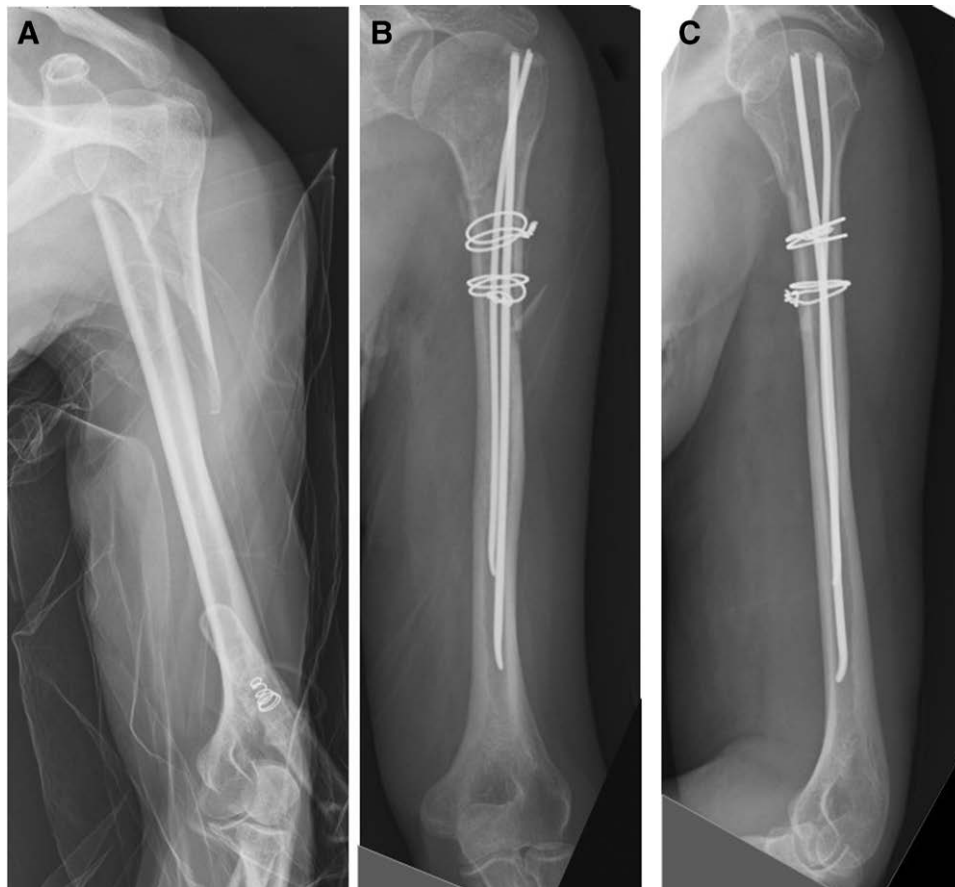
A 46-y-old woman with a long oblique fracture of the proximal humerus. A, Preoperative X-ray, (B, C) post-operative X-ray showed fixation with two cerclage wires, and 3.5-mm titanium elastic nails that were inserted in an antegrade manner without rotator cuff injury.
